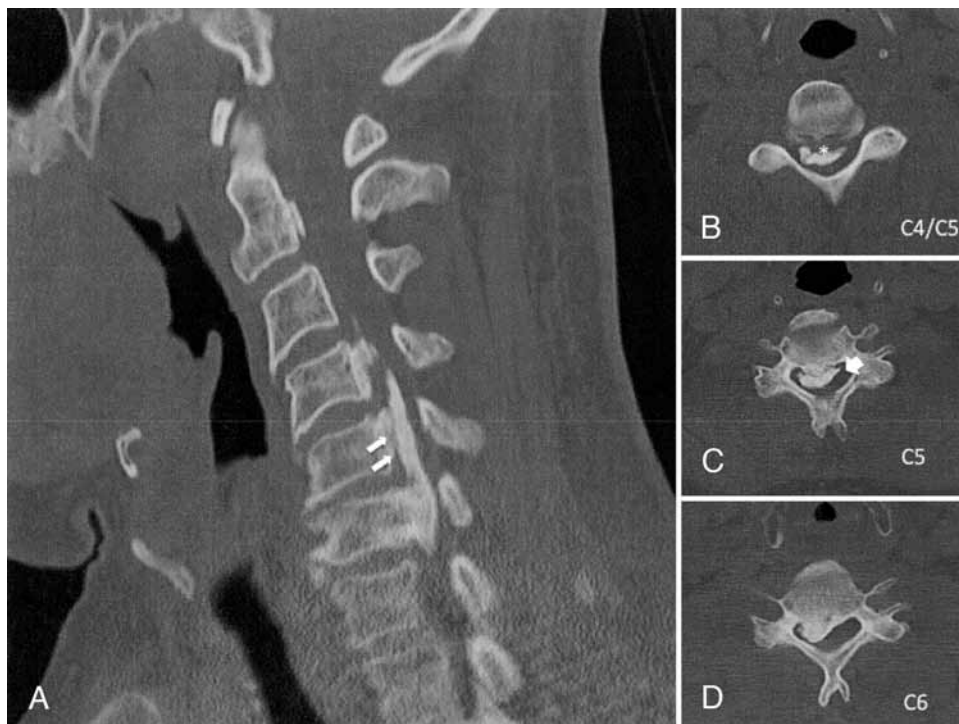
A: Preoperative midline sagittal CT scan obtained in a 53-year-old man, demonstrating segmental and continuous regions of ossification starting at the C3–4 level and extending to C6–7. The patient's relative kyphosis was believed to be a contraindication to an anterior approach. B–D: Axial CT images obtained in the same patient showing an ossified bar (asterisk) with an associated pearl of calcification (B), “double-layer” sign (arrow), consistent with dural ossification (C), and a lateral bar of ossification leading to right-sided compression (D).
